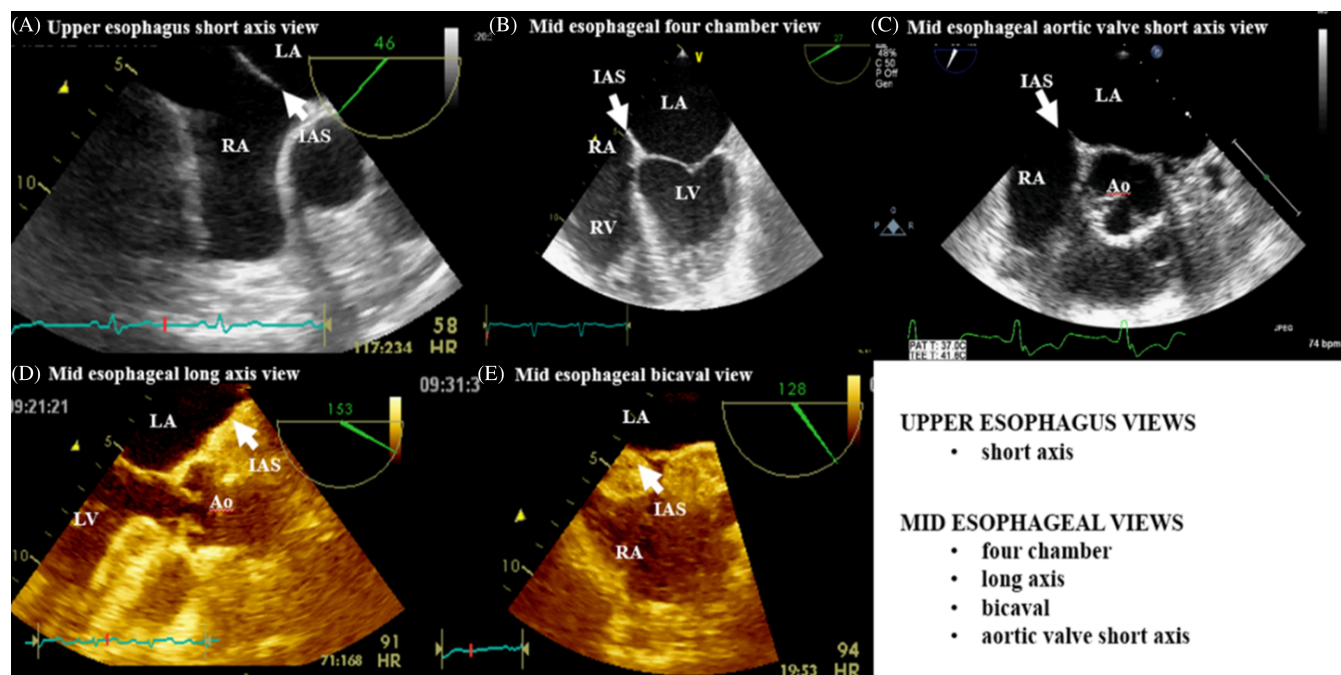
The views for interatrial septum evaluation in transesophageal echocardiography. (A) Upper esophagus short axis view; (B) Mid esophageal four chamber view; (C) Mid esophageal aortic valve short axis view; (D) Mid esophageal long axis view (lipomatous hypertrophy of the interatrial septum); (E) Mid esophageal bicaval view (lipomatous hypertrophy of the interatrial septum). Ao, aorta; IAS, interatrial septum; LA, left atrium; LV, left ventricle; RA, right atrium; RV, right ventricle
